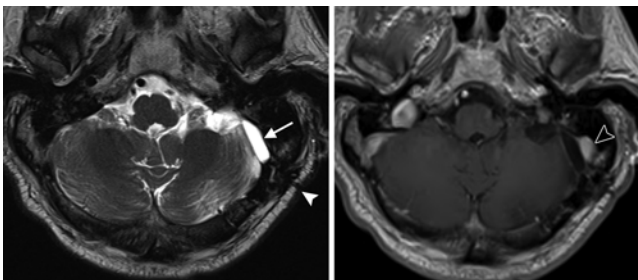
Retrosigmoid resection. Axial T2-weighted (left) and post-contrast T1-weighted (right) MRI studies showing the left retrosigmoid approach with a simple lenticular-shaped extraaxial fluid collection (arrow) overlying the left cerebellar hemisphere. The left postauricular incision (white arrowhead) is posterior to the left sigmoid sinus (black arrowhead).
